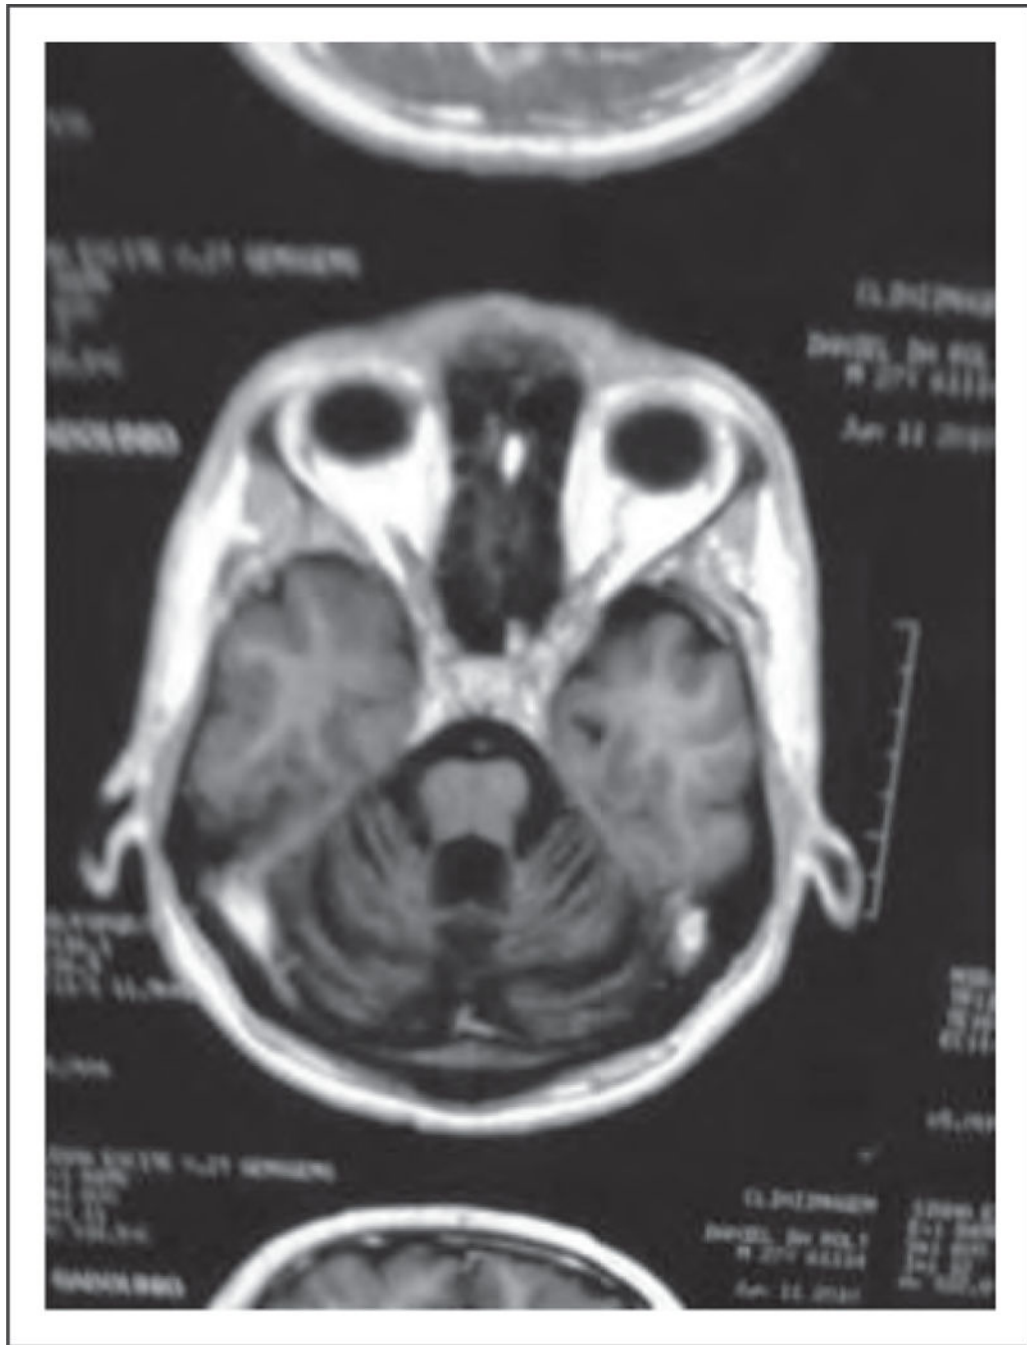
Spinocerebellar ataxia type 34. Brain MRI, axial view, T1-weighted, showing cerebellar atrophy. Adapted with permission.
